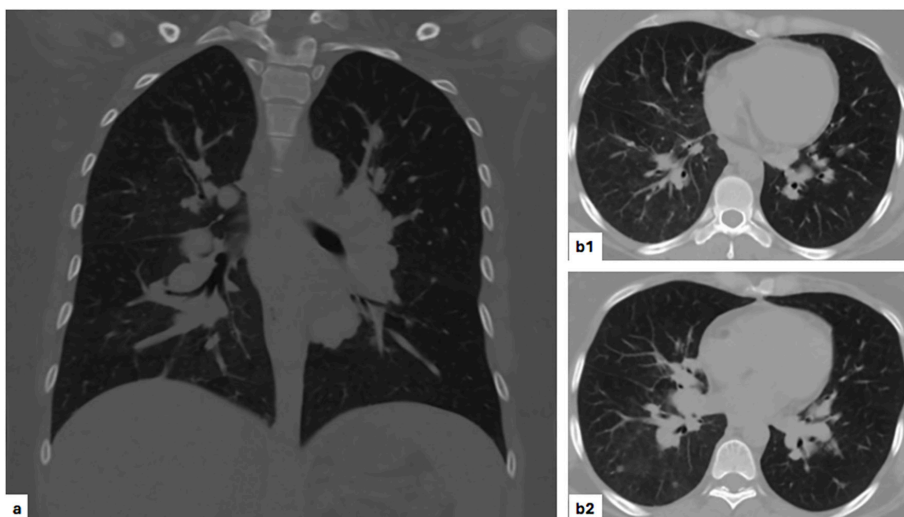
Coronal chest CT performed with high-resolution, thin-slice reconstructions, showing bilateral hilar and mediastinal lymphadenopathy, along with perilymphatic parenchymal nodules, consistent with systemic sarcoidosis [sagittal (a) and axial (b1, b2)]
